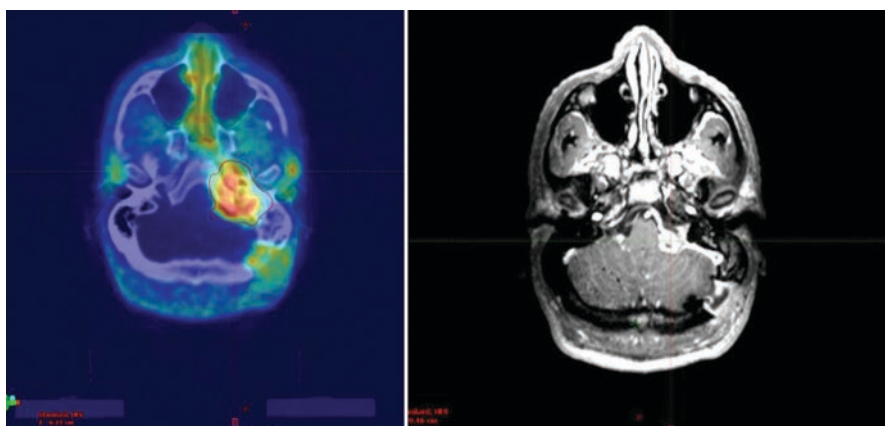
Tumour extension at the level of the skull base on RT planning ^{68}Ga -DOTATATE PET/CT (left) in comparison with CE-T1 MRI (right)
